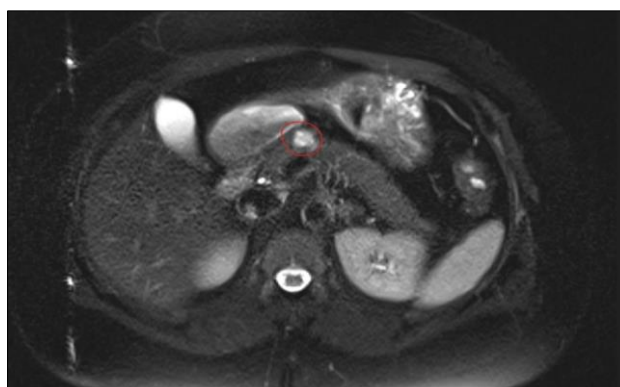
Axial MRI of the pancreas revealing a T2-hyperintense lesion measuring 2 cm x 2 cm in the isthmus of the pancreas
